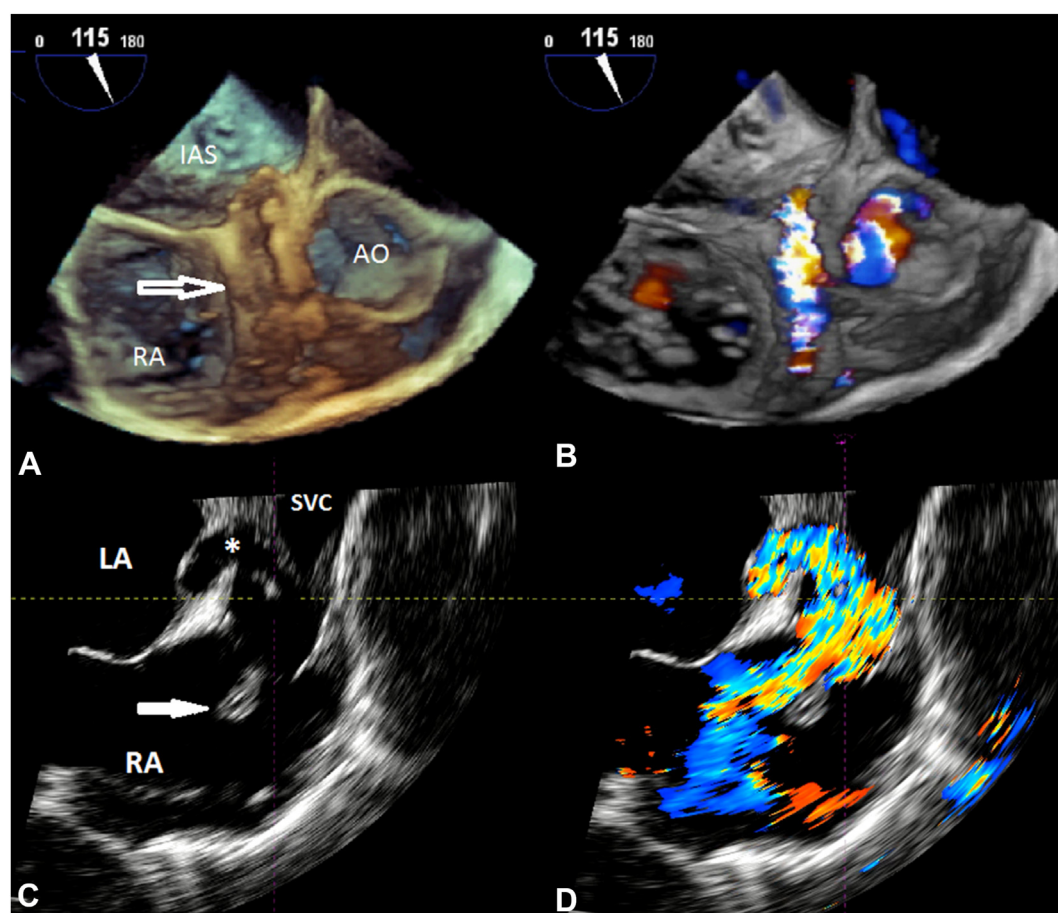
Three-dimensional TEE, midesophageal volume-rendered short-axis views without (A) and with (B) color flow Doppler and multiplanar reconstructed orthogonal views without (C) and with (D) color flow Doppler, demonstrates the fistula tract (*open arrow*) draining into the RA near the superior vena cava (SVC; *asterisk*) and a large vegetation (*closed arrow*) at the drainage site in the RA. AO, Aorta; IAS, interatrial septum; LA, left atrium.
